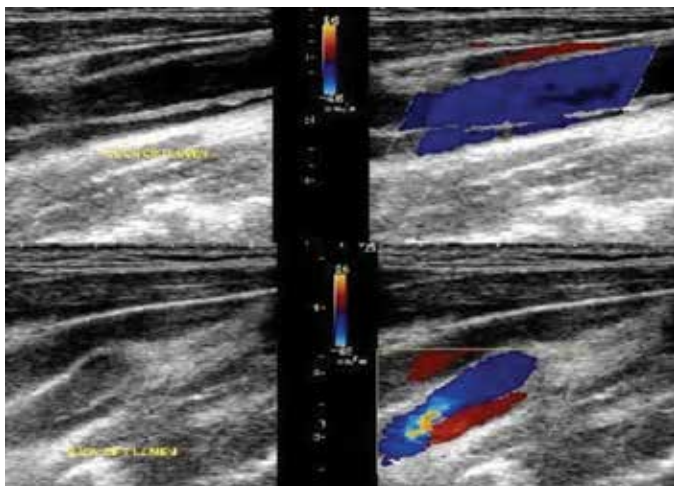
Carotid Doppler study of the first case showing the double-lumen in the right arteria carotis communis and arteria carotis interna
